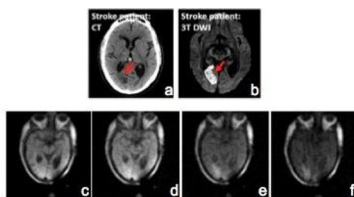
CT, 3T DWI MRI and FFC-MRI images from a patient admitted with a right occipital infarct. a) CT at 24 hours after onset, b) 3T DWI images at 78 hours after onset. c-f) FFC-MRI images at 200 mT, 20 mT, 2 mT and 0.2 mT
